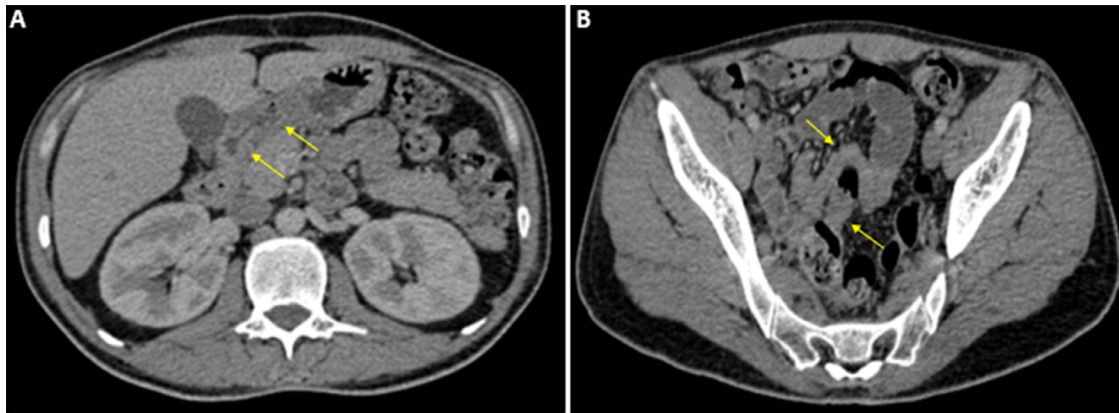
Postcontrast abdominal and pelvic CT showing a complete regression of the wall thickening of the gastro-duodenal and ileal tract, within 2 months after chemotherapy.
